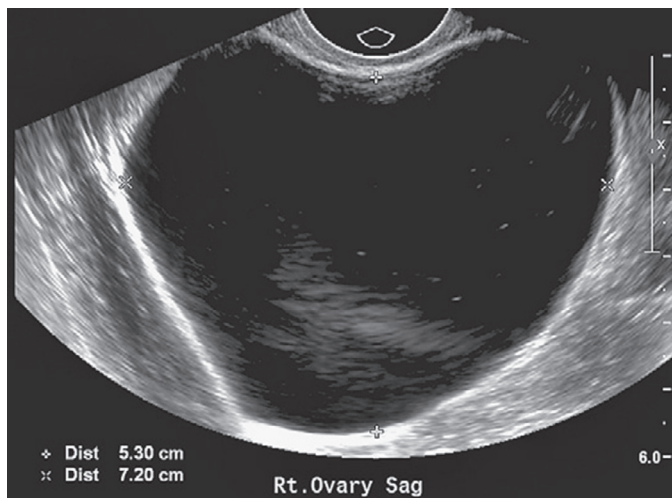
Endovaginal ultrasound image of a follicular cyst, with smooth wall and posterior wall enhancement. (From Cicchiello LA, Hamper UM, Scutt LM: Ultrasound evaluation of gynecologic causes of pelvic pain. *Obstet Gynecol Clin North Am.* 38:85–114, 2011.)
